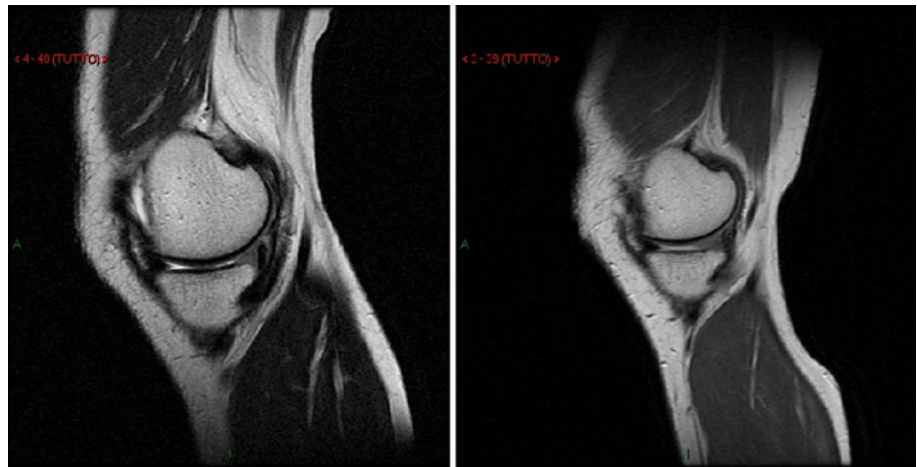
MRI evaluation of a medial polyurethane meniscal scaffold at 12 months (*left*) and 24 months (*right*) of follow-up
